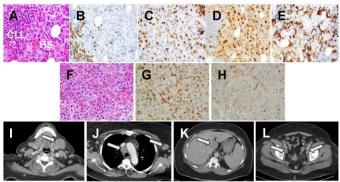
Pathologic and radiographic evidence of concurrent CLL and secondary HS in Patient 3. Bone marrow core biopsy reveals small round CLL cells and large, pleomorphic cells with irregular nuclei and abundant cytoplasm (A) that are PAX5- (B), lysozyme+ (C), cyclin D1+ (D), and rarely CD163+ (E), consistent with HS. Submandibular lymph node biopsy is also consistent with HS, without evidence of CLL, showing large pleomorphic cells (F) that are cyclin D1+ (G), and CD68+ (H). Axial cross-sections of contrast-enhanced CT demonstrate multi-station lymphadenopathy (white arrows), including cervical (I), mediastinal and axillary (J), periportal (K), and pelvic nodes (L). The largest lymph node is 4 cm in short-axis at the porta hepatis (K). Mild splenomegaly is also seen (K).
